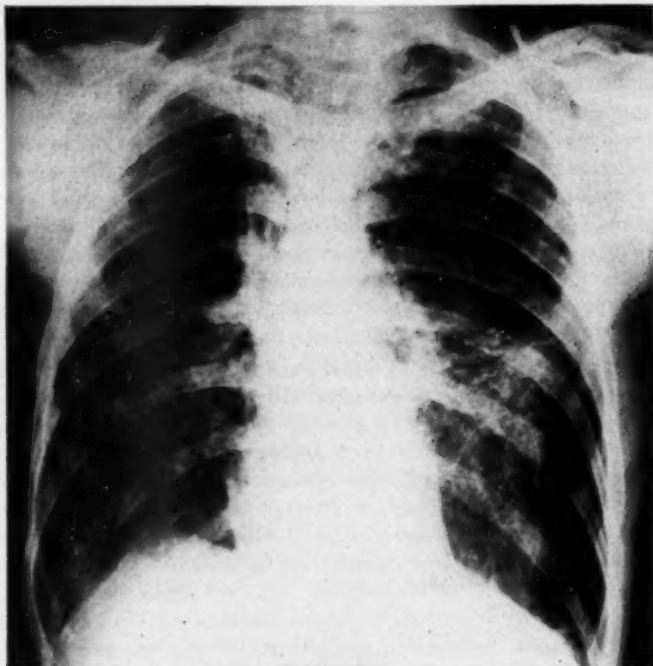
Roentgenogram of chest showing rather dense infiltration of both lung fields, suggestive honeycombing, and spontaneous pneumothorax on the left side (below pleural adhesion). The patient was a young man, 29 years of age, who had complained of persistent dry cough and chest pain for several years. This picture, while not pathognomonic, is frequently observed in chronic disseminated histiocytosis X (S-C).
